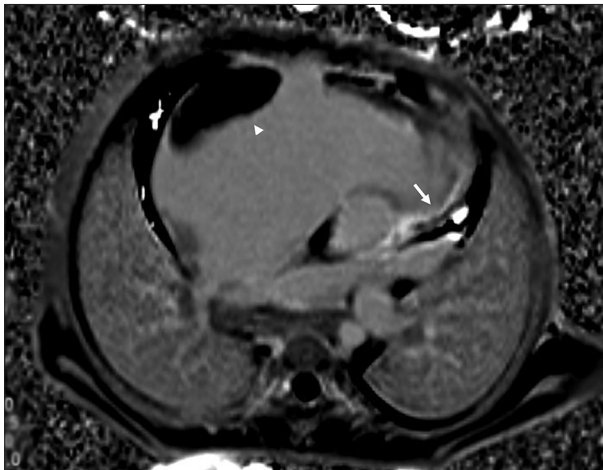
Cardiac magnetic resonance image showing obliteration of right ventricular apex with subendocardial late gadolinium enhancement in the right ventricular wall (arrow). Grossly dilated right atrium with right atrial thrombus (arrowhead) are also noted
